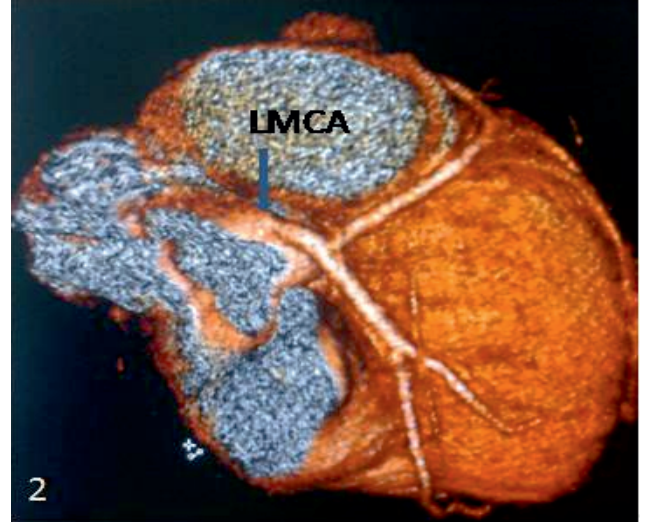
Normal LMCA ostium on CT angiography
